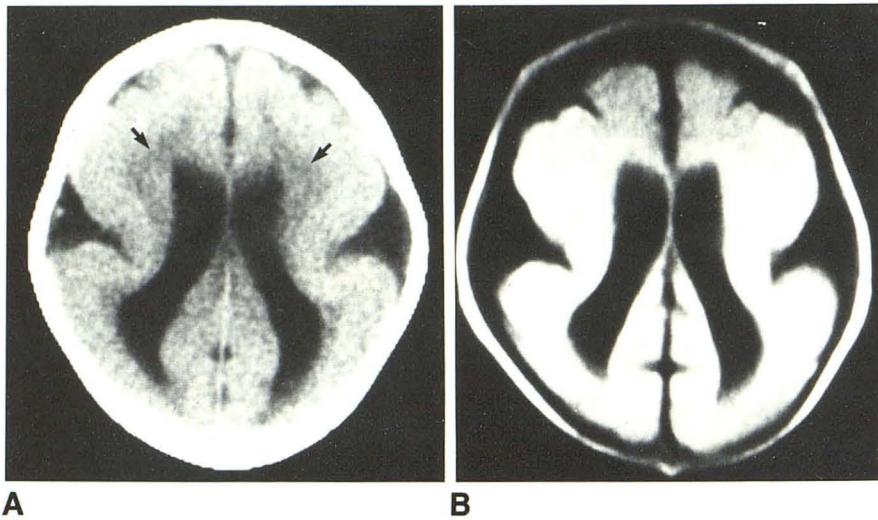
Axial CT scan (A) and MR image, 500/30 (B). Almost completely agyric brain with pachygyric areas involving frontal lobes, hourglass configuration with abnormal sylvian areas, increased cortical gray matter and decreased white matter (arrows), lack of cortical white matter interdigitations, and colpocephaly.
